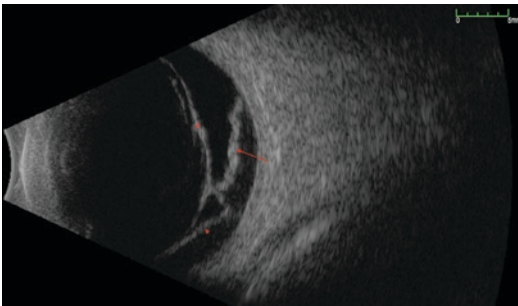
Ophthalmic brightness amplitude scan (B-scan) ultrasound of a combined tractional and rhegmatogenous retinal detachment. B-scan demonstrating a macular involving retinal detachment with rhegmatogenous (arrow) and tractional (arrowhead) components with associated attachment points to the posterior hyaloid face (asterisks) in a patient with proliferative diabetic retinopathy
